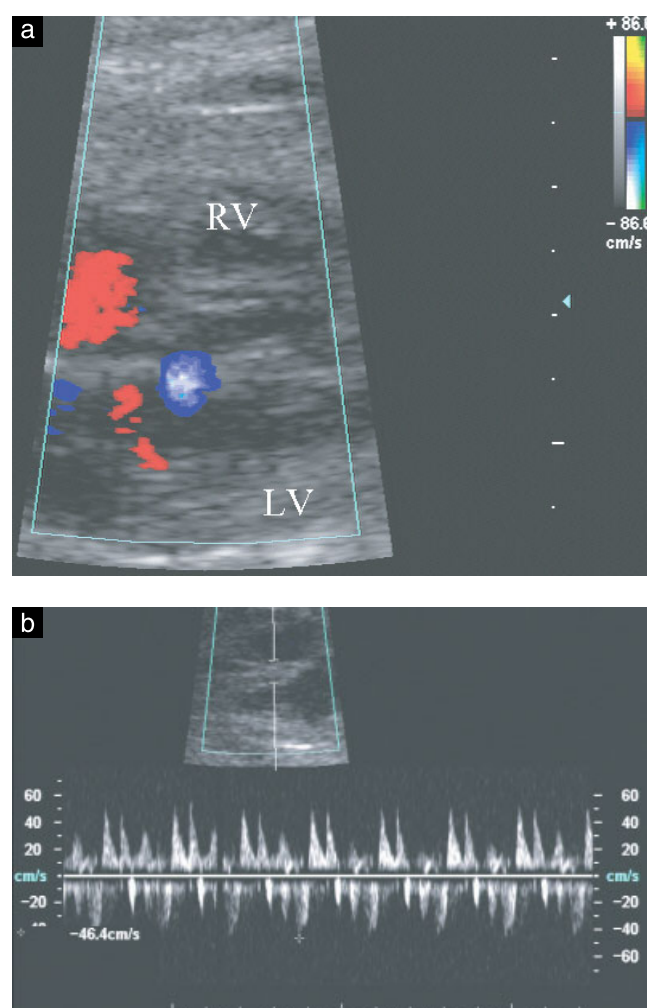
Color Doppler ultrasound images showing (a) small perimembranous septal defect and (b) the characteristic bidirectional flow pattern detected by spectral Doppler of the interventricular jet. LV, left ventricle; RV, right ventricle.
